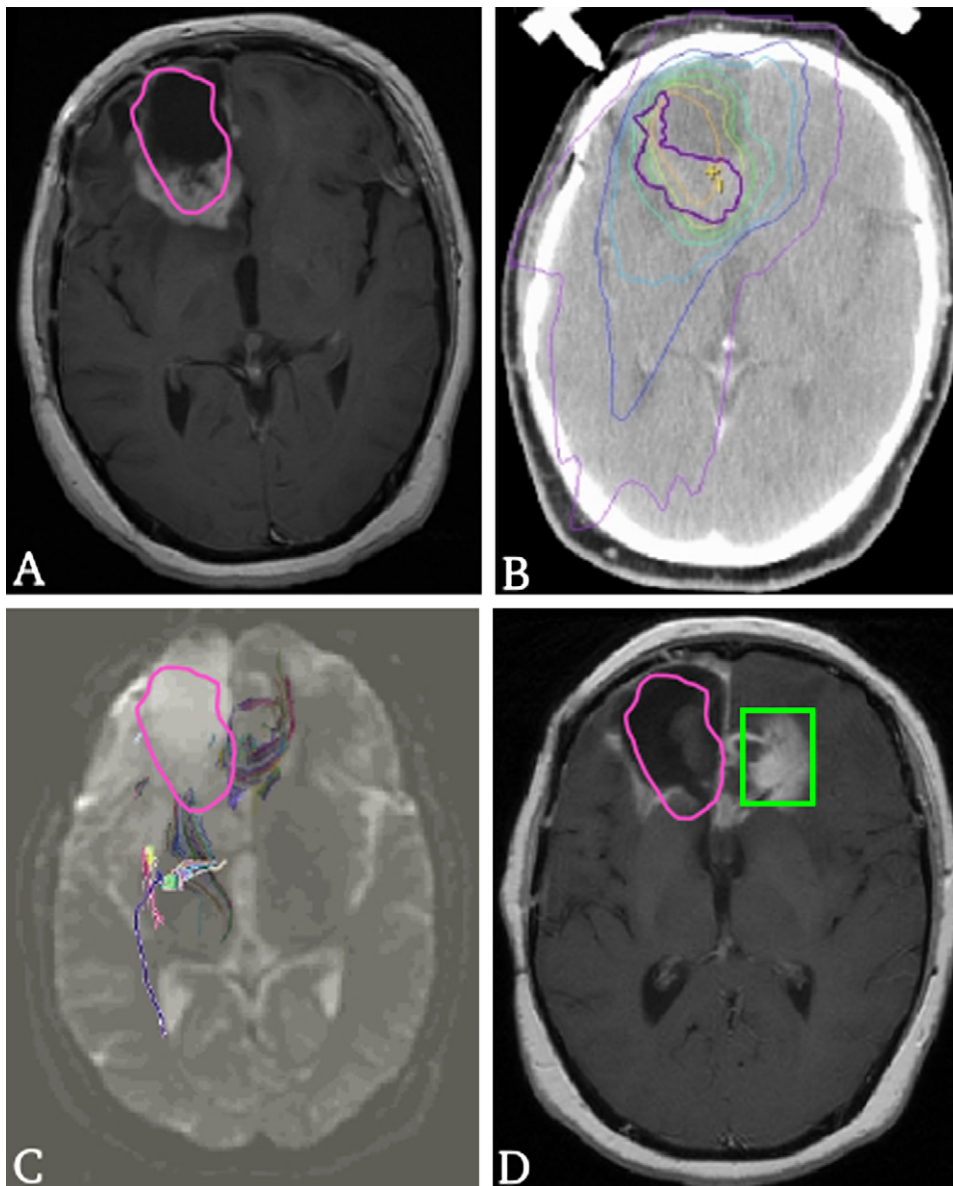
(A) T1-weighted contrast image showing the primary glioblastoma multiforme and treatment margin (pink line = 90% isodose) obtained from the treatment plan by computed tomography (green line) (B). Surgical resection of the primary tumor (A) occurred approximately 10 months before the radiation treatment plan depicted in (B). (C) Diffusion tensor imaging reference image ($b = 0$) taken at the same time point (A), showing all diffusion paths passing through the tumor, the genu of corpus callosum, and internal capsule. (D) T1-weighted postcontrast image acquired 8 months after the time point of (A) showing progressive disease (green box) located just outside of the treatment margin, having spread along the genu of the corpus callosum as predicted in (C).
